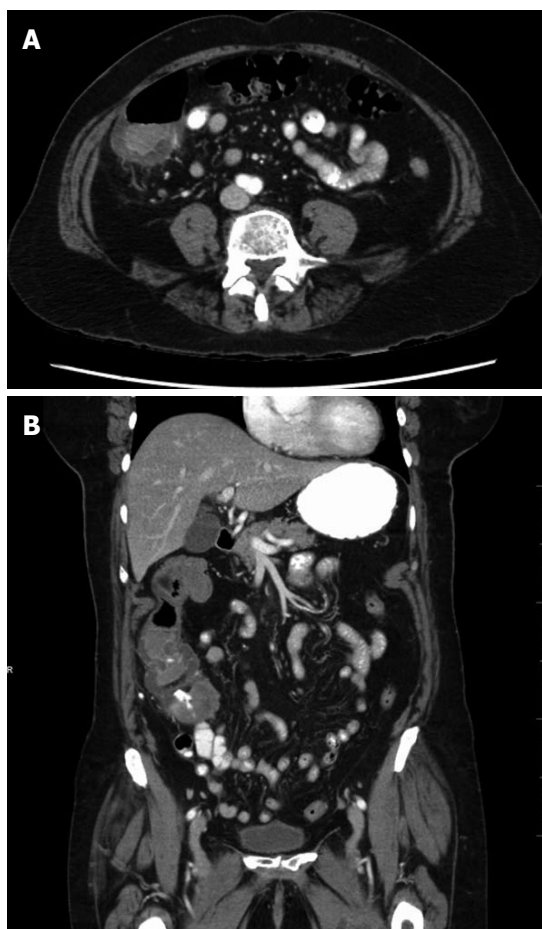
Computed tomographic scan images of contained colonic perforation suspected secondary to cecal retroflexion. The cecum with an associated contained fluid collection is shown in axial (A) and coronal (B) views.
